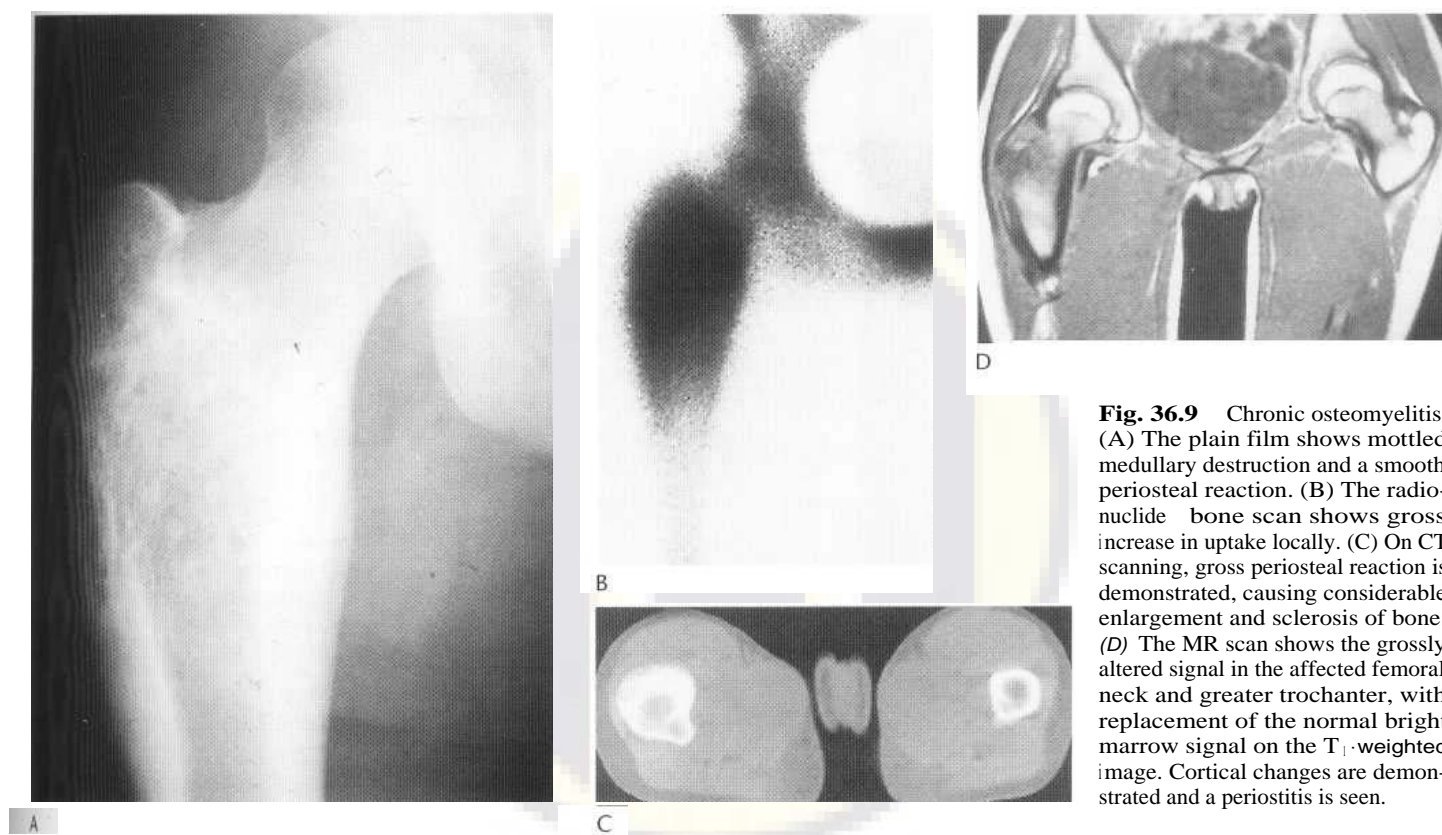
Chronic osteomyelitis. (A) The plain film shows mottled medullary destruction and a smooth periosteal reaction. (B) The radio-nuclide bone scan shows gross increase in uptake locally. (C) On CT scanning, gross periosteal reaction is demonstrated, causing considerable enlargement and sclerosis of bone. (D) The MR scan shows the grossly altered signal in the affected femoral neck and greater trochanter, with replacement of the normal bright marrow signal on the T_1 -weighted image. Cortical changes are demonstrated and a periostitis is seen.
